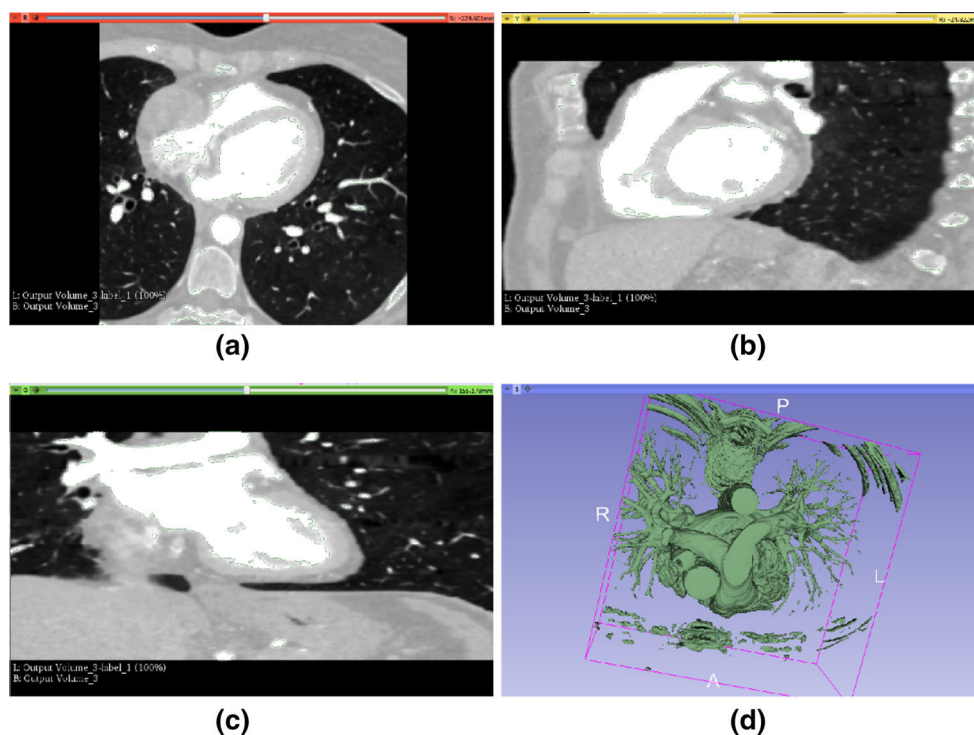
CT scan with contrast in diastolic phase: a axial view; b sagittal view; c coronal view; d rough 3D reconstruction from originally acquired images (i.e. without post processing phases), demonstrating the necessity of enhancing and restoring the input image prior to proceed with 3D model reconstruction
